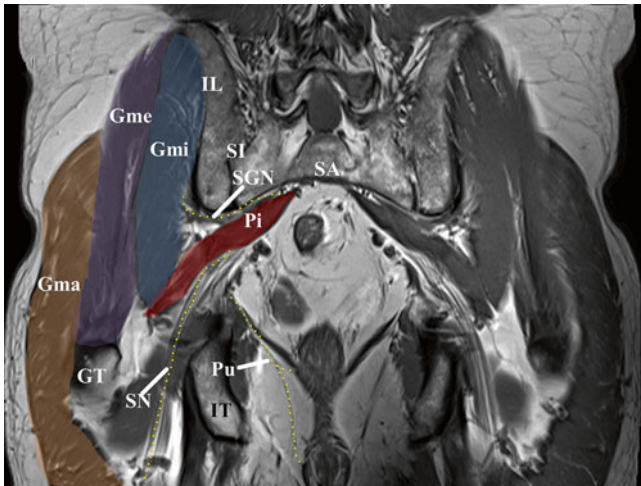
MRI coronal image. SA sacrum, SI sacroiliac joint, IL ilium, IT ischial tuberosity, GT greater tuberosity, Gmi gluteus minimus, Gme gluteus medius, Gma gluteus maximus, PI piriformis, SGN superior gluteal nerve, SN sciatic nerve, PU pudendal nerve (Image created by Andrea Trescot, MD)
